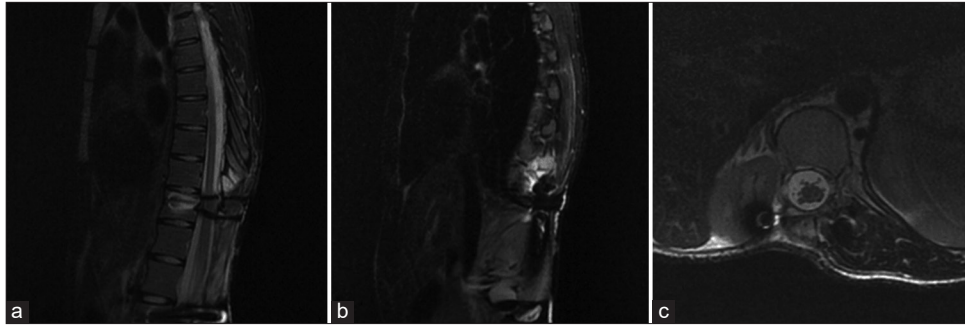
Preoperative magnetic resonance imaging. (a) Midsagittal T2-weighted image (T2WI) with fat suppression revealing a hyperintense lesion causing medullary invasion at the T12–L1 levels. (b) Midsagittal T2WI with fat suppression showing a hyperintense expansive lesion in the right paravertebral area. (c) Axial T2WI with fat suppression revealed a significant spinal cord compression by the tumoral mass.
